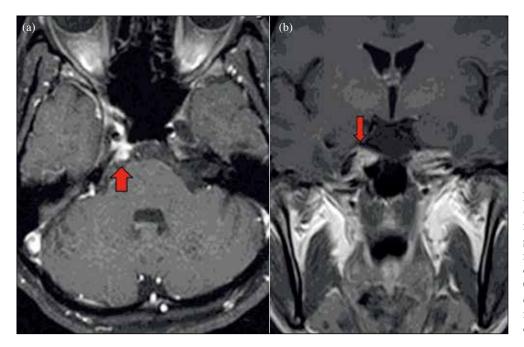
Patient 1: (a) Axial and (b) coronal T1-weighted highresolution fat-suppressed postgadolinium contrast magnetic resonance images along the course of abducens nerve revealing a $0.9 \times 0.9 \times 0.9$ cm contrast-enhancing extra-axial mass (arrows) at the right retroclival region along the course of Dorello canal.
